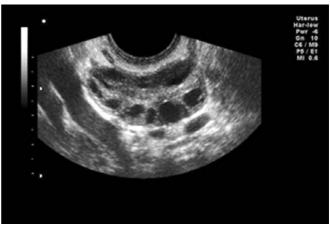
Normal ovary by ultrasound
